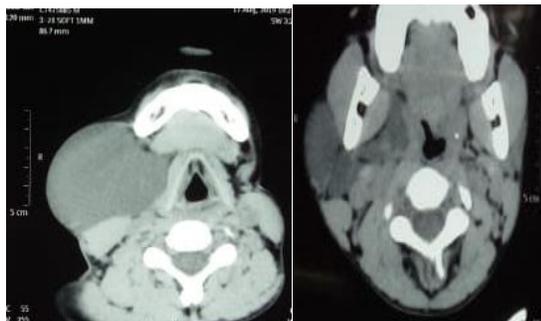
(b): CT scan showing of cystic lesion arising from lateral wall of nasopharynx extending to right parapharyngeal area, abutting right common carotid artery, medially to thyroid.
